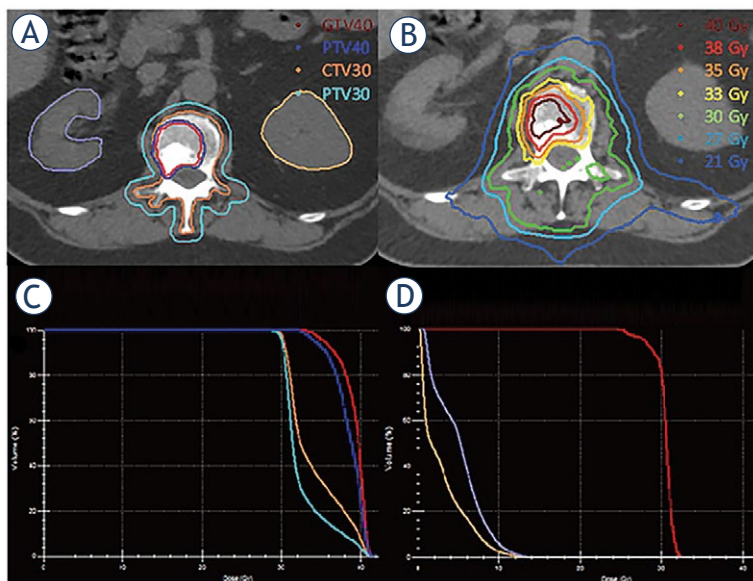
Example of a radiation plan for a bone metastasis in the first lumbar vertebra. Gross tumour volume (GTV)40 was contoured by coregistered diagnostic positron emission tomography-computed tomography (PET-CT). Clinical target volume (CTV)30 included GTV40 and the whole vertebral body. Planning target volume (PTV)40 and PTV30 were generated with 2 and 5 mm margins (A). Panel (B) demonstrates isodose distribution. Dose-volume histograms (DVHs) PTV30, PTV40, CTV30 and GTV40 show dose coverage (C). GTV40 coverage is compromised due to spinal cord sparing (B, C). DVHs for both kidneys (purple and yellow), as well as spinal cord (red) are demonstrated as well (D). Medical history: patient was diagnosed with high-risk prostate cancer in 2012. Initial treatment included the combination of radiotherapy (prostate and pelvic lymph node) and long-term androgen-deprivation therapy. A single metastasis in the first lumbar vertebra was diagnosed in 2018. Radiotherapy with 30/40 Gy in 10 fractions with integrated simultaneous integrated boost (SIB) was applied for better local control. By the last documented follow up in 2021, no progression was observed in the irradiated metastasis. However, the patient developed diffuse skeletal metastases (treated with secondary androgen-deprivation therapy with abiraterone and enzalutamide).
